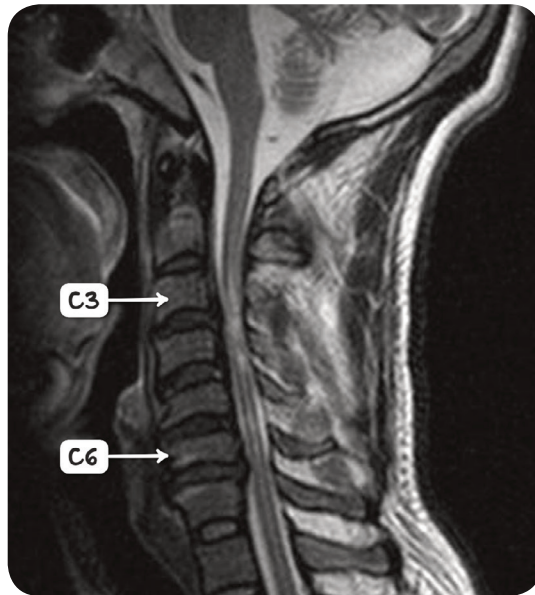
An MRI scan of the cervical spine demonstrating spinal stenosis from C3 to C6 resulting in cord compression.
